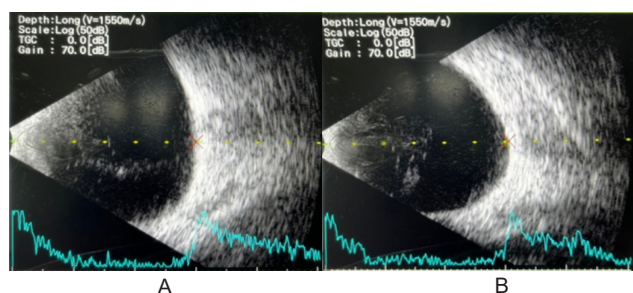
Eye ultrasound of the first patient's (A) right eye and (B) left eye.
